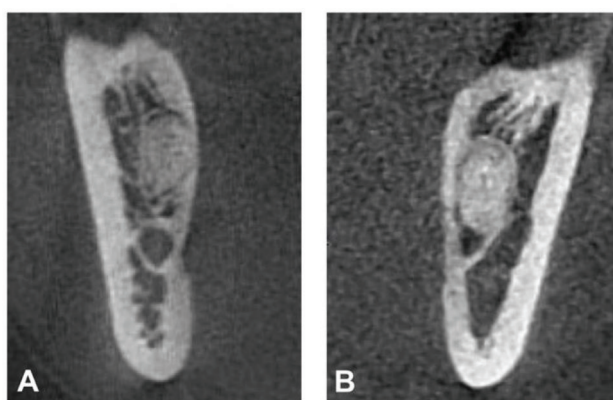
Evaluation of nerve involvement on CBCT. (A) Complete radiopaque ring of canal (no contact), (B) Discontinuity of radiopaque ring of canal (contact).
